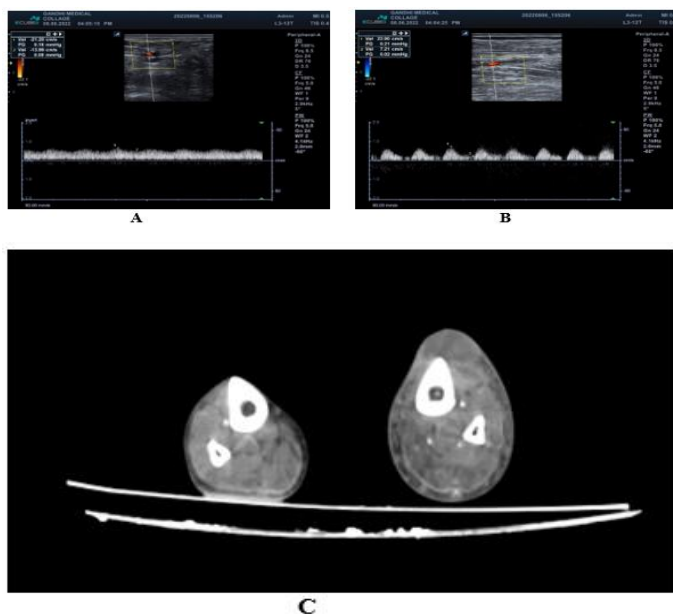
46 years old smoker & hypertensive patient, came with right leg claudication (A) Colour doppler study shows moderate stenosis of right PTA with spectral broadening & monophasic spectral pattern (B) Colour doppler study shows mild stenosis of right peroneal artery with slightly reduced colour flow & biphasic spectral pattern (C) CT angiogram axial section shows filling defect in right PTA & peroneal artery likely due to thrombus, bilateral ATA, left PTA & left peroneal artery shows normal contrast opacification.
